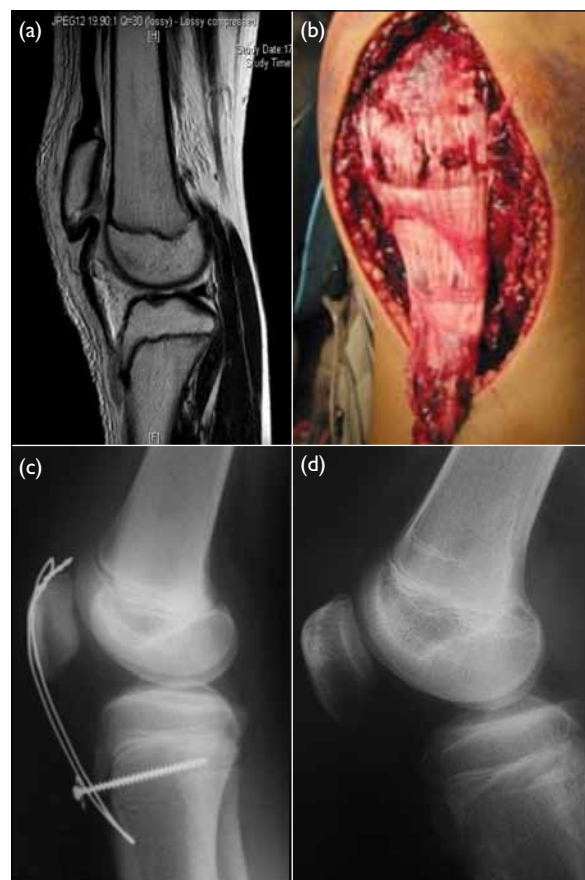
(a) Magnetic resonance imaging showing avulsion of right patellar tendon with patella alta and intact physal plate. (b) Intra-operative photo showing the avulsed end of the right patellar tendon. (c) Lateral radiograph of right knee early after operation. (d) Lateral radiograph of right knee after 12 months of follow-up
